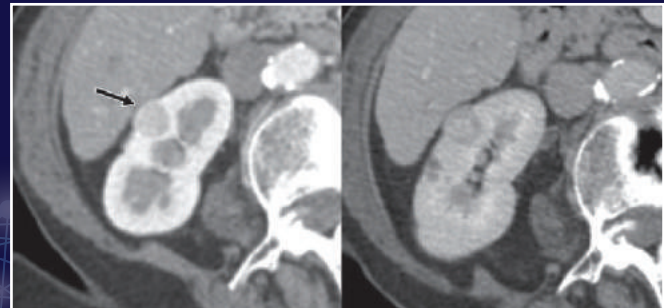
CT Scan showing a Bosniak type IV cystic lesion (arrow) with thick enhancing walls. Minimal perinephric fat stranding is also present.
